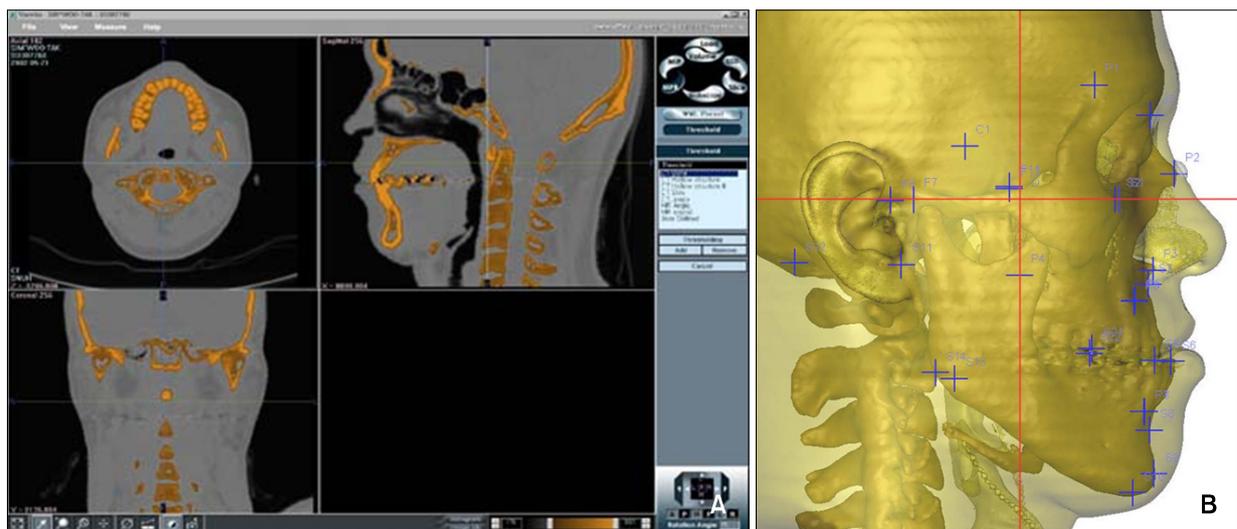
Acquisition of projected images from CT data. A, Segmentation of skull and skin part using V works; B, projected image to midsagittal plane. By reducing the transparency of the skin part, the projected image looks more like a cephalometric radiograph.
